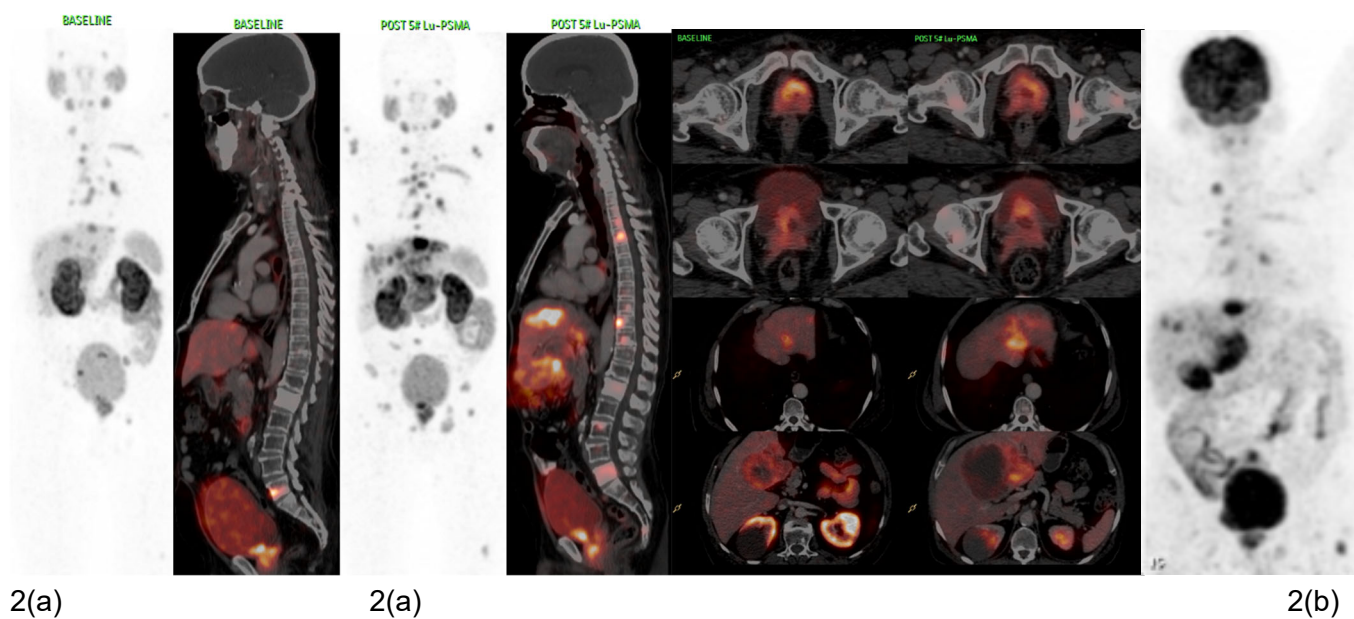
(a) Comparative analysis of  $^{68}\text{Ga}$ -PSMA-11 PET/CT scans at baseline and post- $^{177}\text{Lu}$ -PSMA-617 therapy of Case II. (b) Maximum intensity projection (MIP) of baseline FDG-PET/CT scan.
